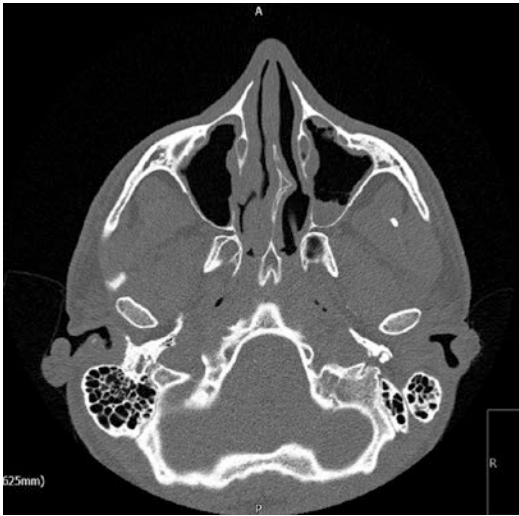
CT of the paranasal sinuses (axial) of the same patient
